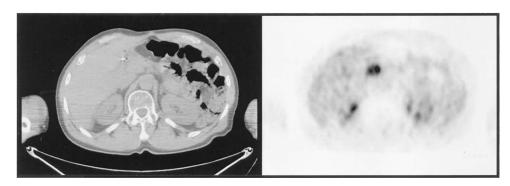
FDG-PET imaging from a patient undergoing surveillance after treatment for gallbladder carcinoma. The FDG-PET images demonstrate FDG uptake corresponding to the gallbladder fossa on the corresponding CT image and indicating local recurrence.
